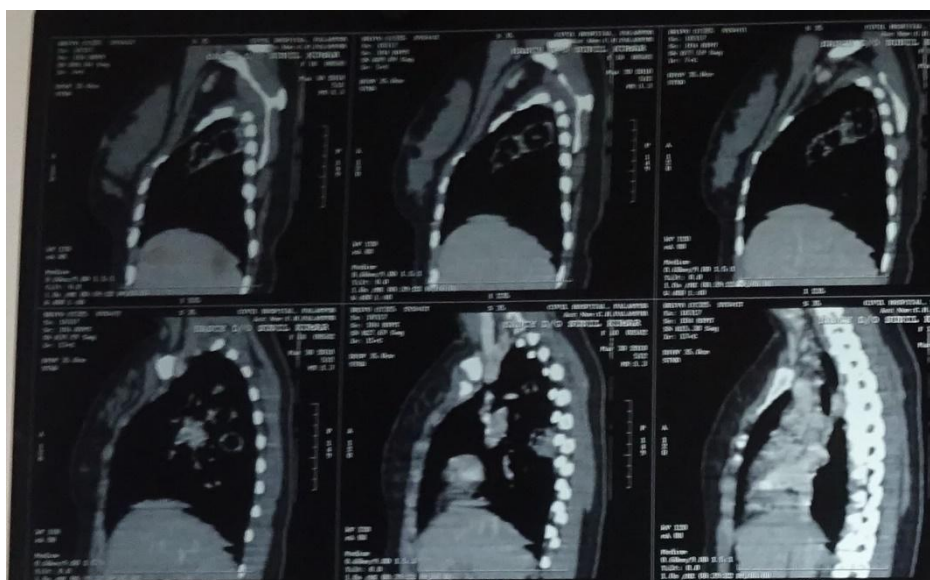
CT scan chest lateral view of the same patient showing multiple nodulocystic lesions.
